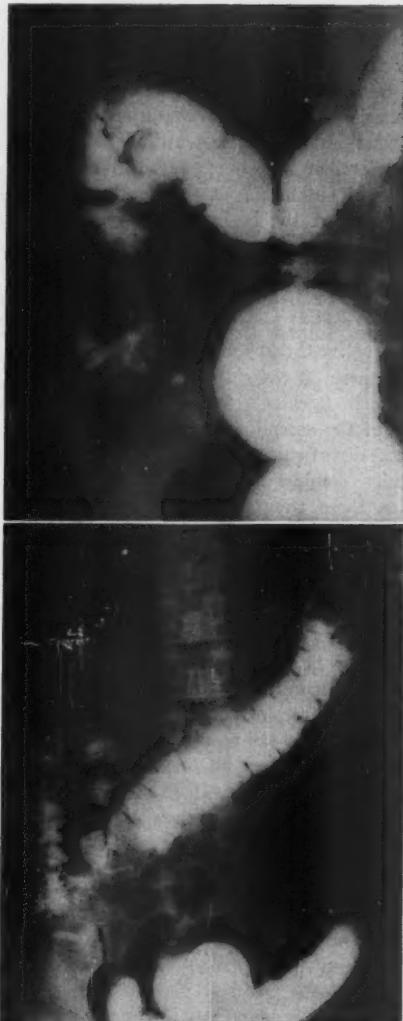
Typical radiographic appearance of cecal diverticulitis. Both cases treated by right hemicolectomy.
